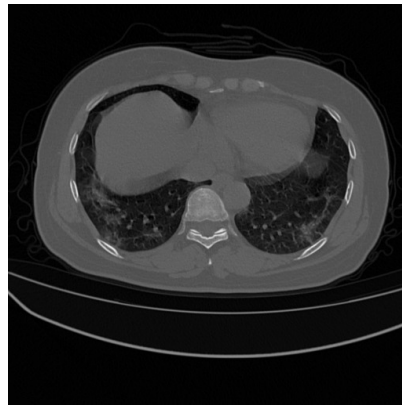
CT scan for a COVID sample [10].
